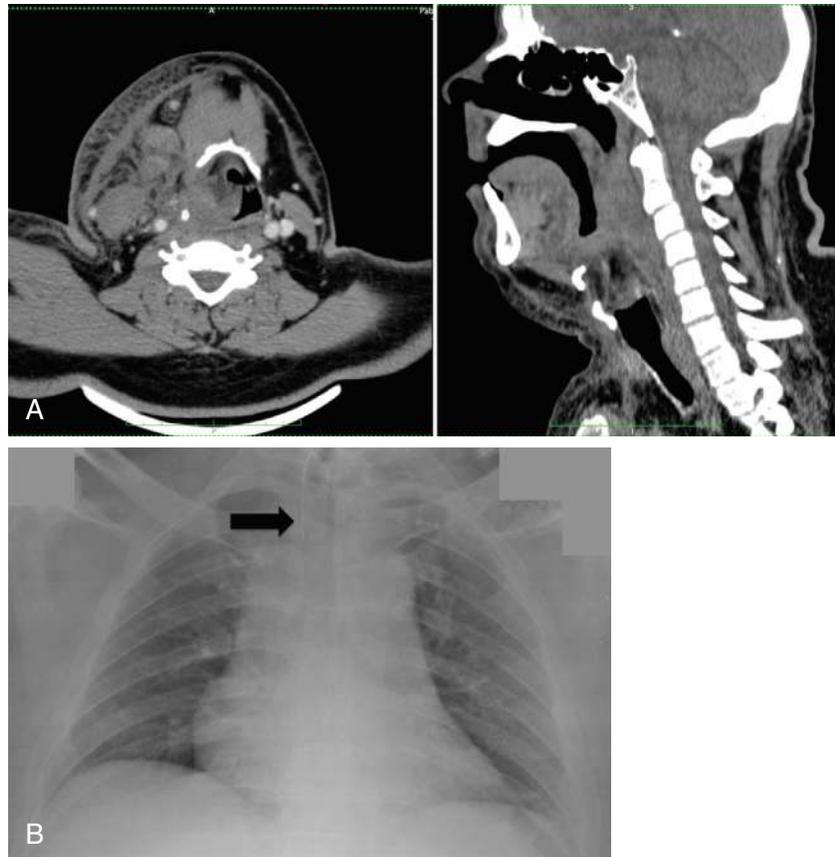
A, CT scan of very severe airway obstruction as a consequence of posttraumatic oropharyngeal hematoma. B, Chest x-ray image after airways control by temporary tracheostomy in perioperative assessment.
